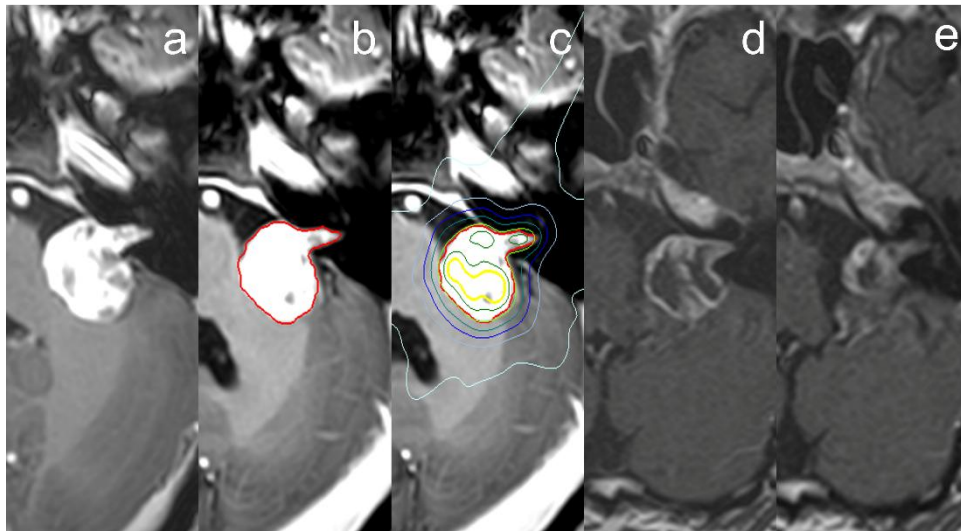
Contrast enhanced T1 MRI of a VS treated with SRS. a) MR image for treatment planning, b) manual segmentation, c) radiation planning with isodoses displayed, d) 6 month follow up MRI, e) 20 month follow up MRI
